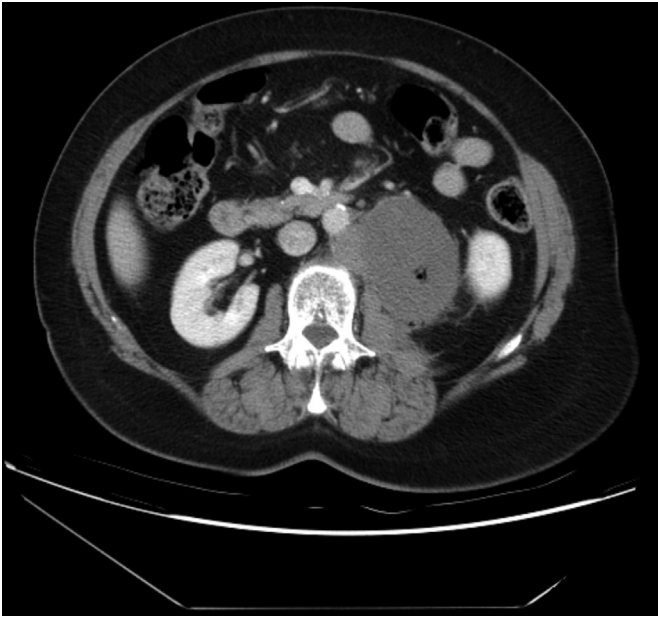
Abdominal CT scan prior to treatment demonstrating a bulky retroperitoneal tumor.
